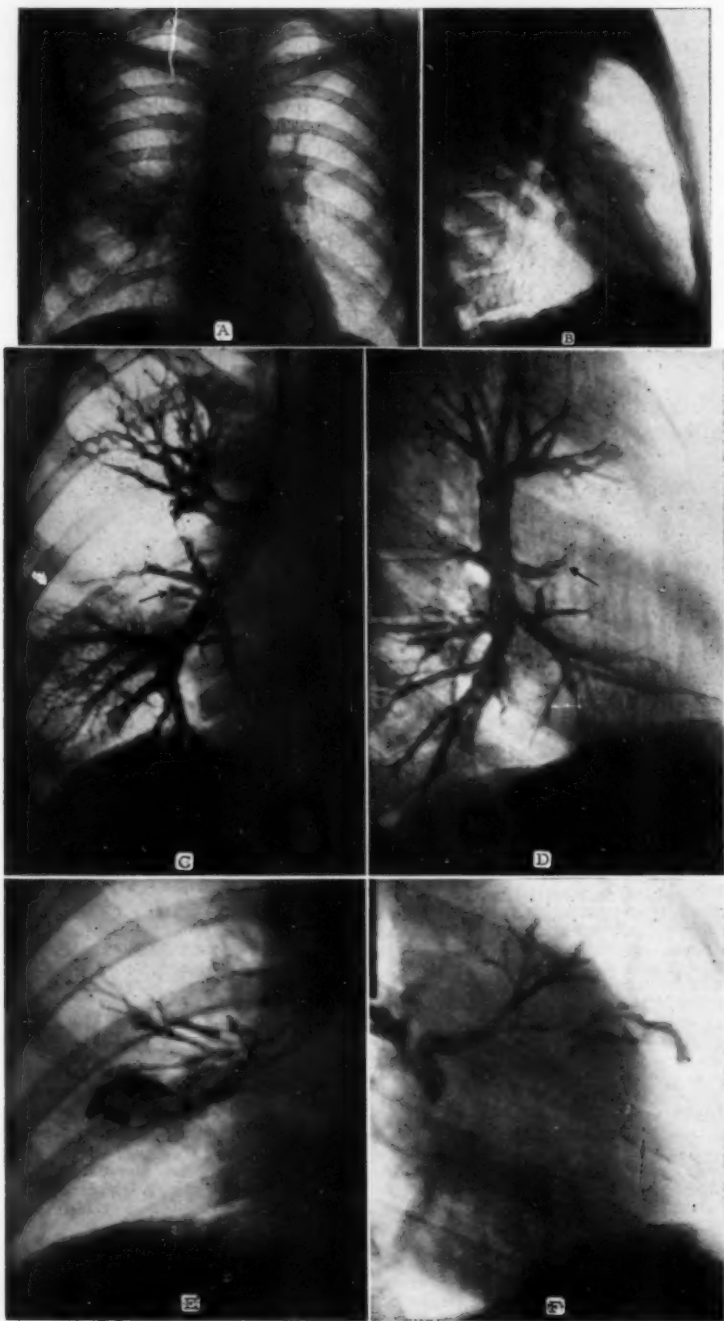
Case 1: AP and lateral roentgenograms (A and B) showing spotted density in the right middle lobe region.
